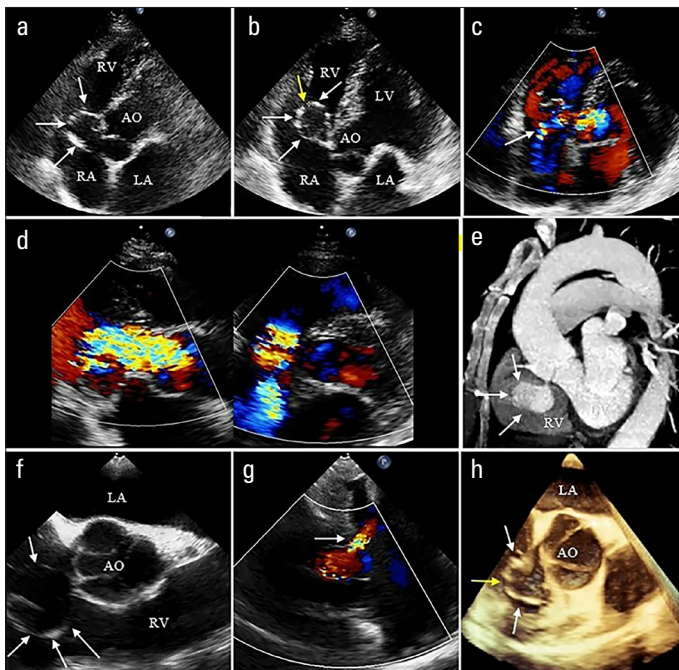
Echocardiographic and CTA images. (a, b) Two-dimensional transthoracic echocardiography revealing a right coronary sinus of Valsalva aneurysm (white arrows) and the defect of the aneurysm wall (yellow arrow). (c) Color Doppler flow imaging disclosing a shunt from the aneurysm to the right atrium (d) Color Doppler flow imaging demonstrating severe aortic and tricuspid regurgitation. (e) CTA showing the aneurysm arising from the right coronary sinus (white arrows). (f, g) Transesophageal echocardiography demonstrating the aneurysm originating from the right coronary sinus (white arrows) and the shunt from the aneurysm to the right atrium (white arrow). (h) Real-time three-dimensional transesophageal echocardiography indicating the aneurysm originating from the right coronary sinus (white arrow) and the defect of the aneurysm wall (yellow arrow)
